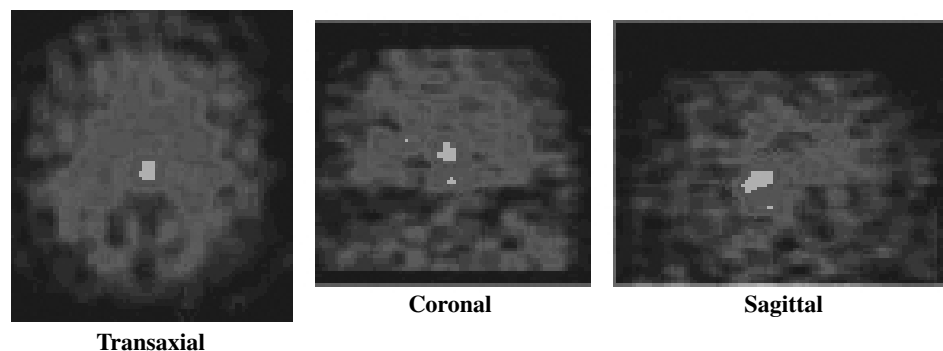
SPECT images of a normal subject's brain at 5 h after injection of [^{123}I]ADAM. (See color insert.)
